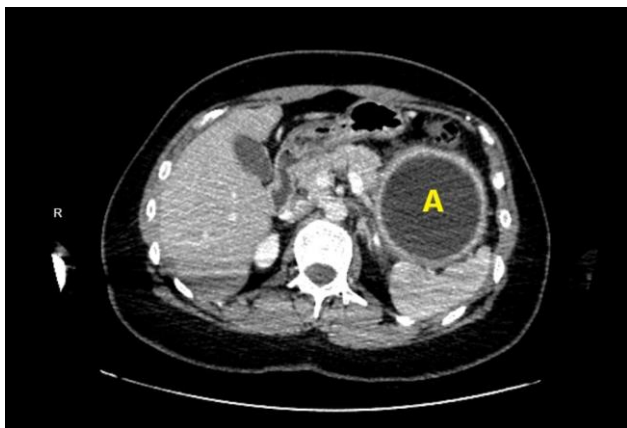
On the CT scan, the intragastric balloon is marked with "A".
